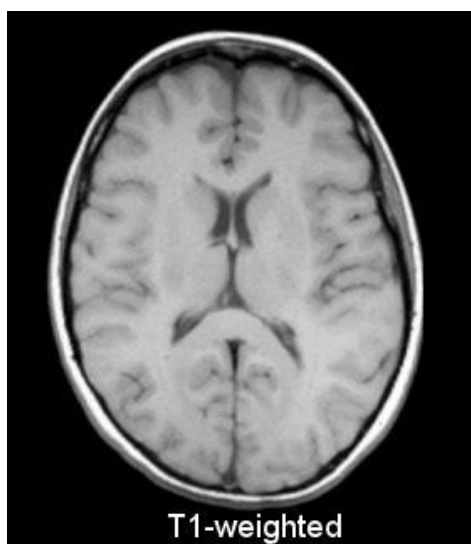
T1-weighted midsection MRI scan.
